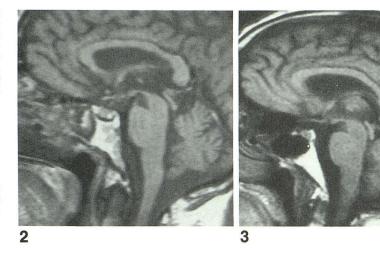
Grade 3 normal clivus in a 61-year-old woman. T1-weighted midline sagittal image, SE 350/30 (0.5 T), shows a normal clivus with uniformly bright signal intensity.
